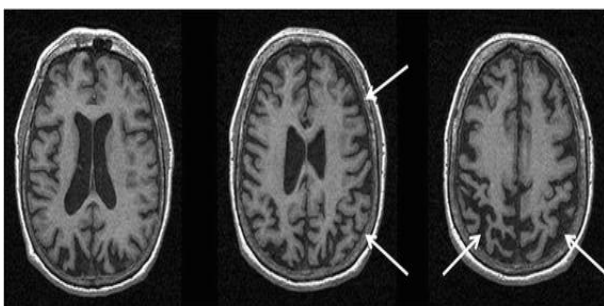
Shows the MRI of the brain imaging.
